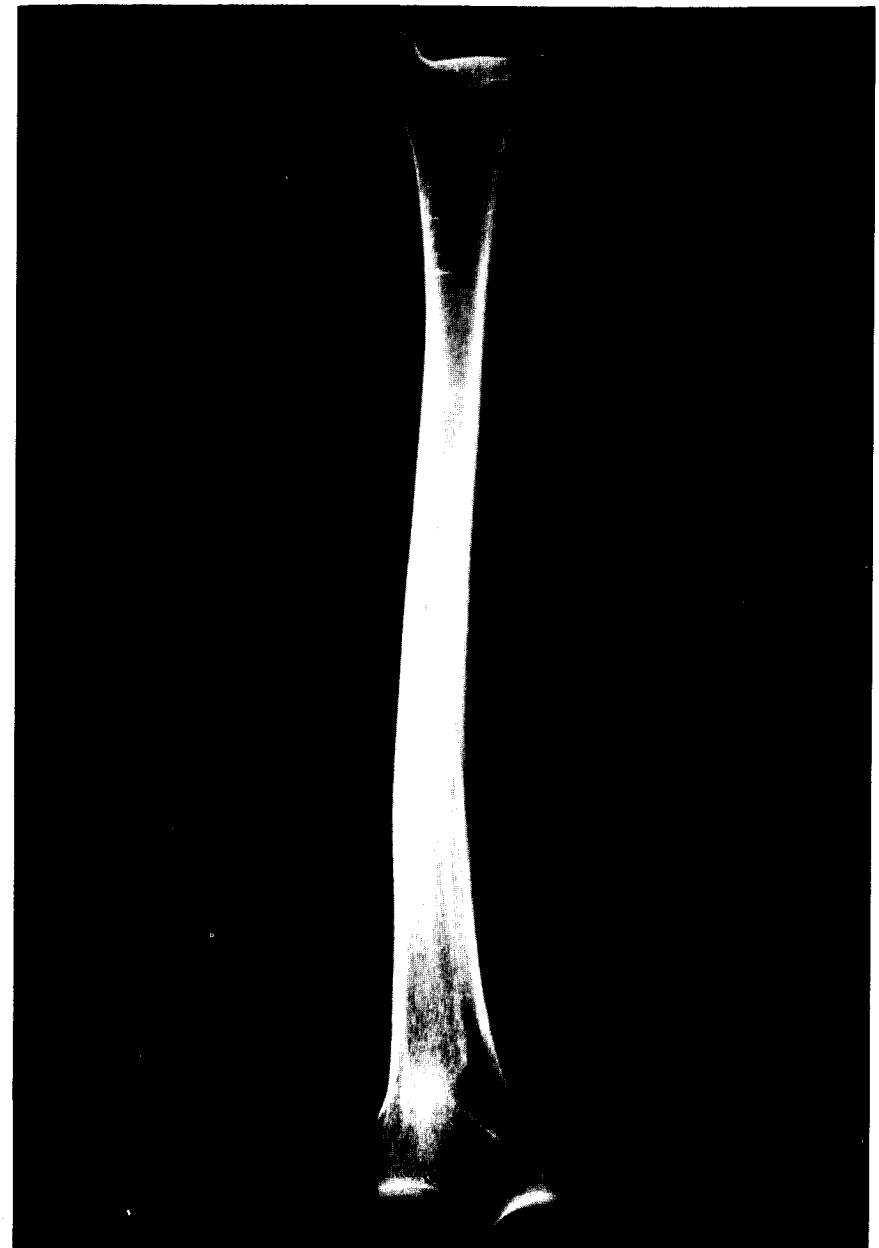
X-ray photograph showing Harris Lines in a tibia.
